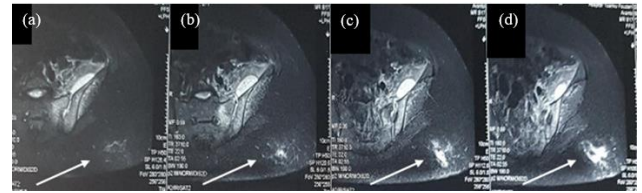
Serial MRI pelvis in sagittal view (2a – 2d) depicting a gluteal collection/ abscess (white arrow) measuring 4.6 cm x 3.0 cm x 3.6 cm.
